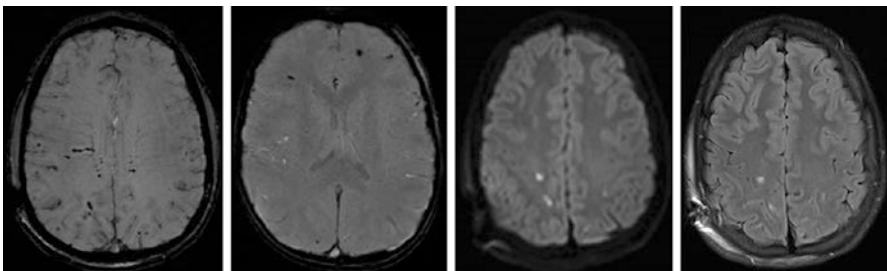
MRI findings in diffuse axonal injury (DAI). The two left images demonstrate microhemorrhages on susceptibility weighted imaging (SWI) in two different patients. The third image demonstrates high signal on diffusion weighted imaging (DWI), and the rightmost image demonstrates the corresponding FLAIR changes
